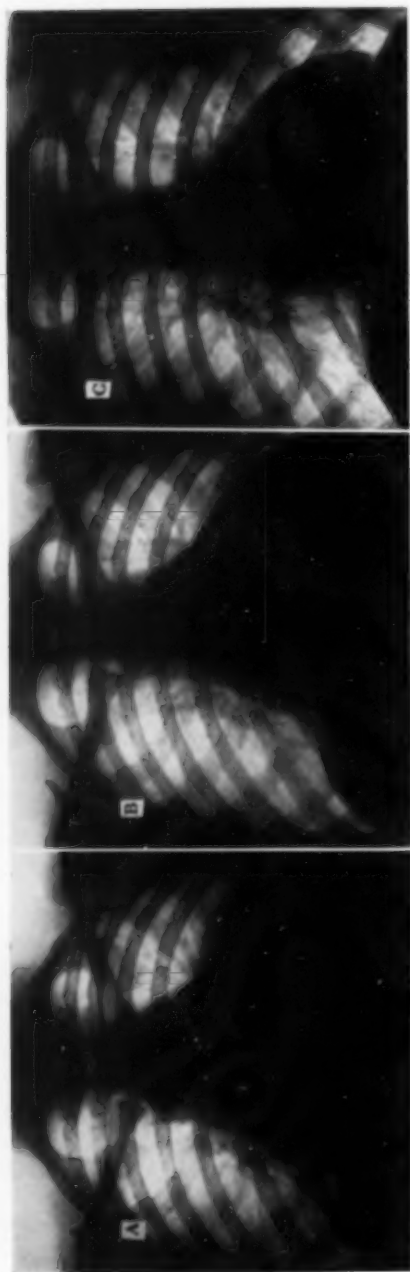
(Case No. 3) Effect of local hydrocortisone acetate on pleural and pericardial effusion: (A) Roentgenogram showing pleural and pericardial effusion before treatment; (B) 8 days after the introduction of 100 mg of hydrocortisone into the left pleural cavity; (C) 9 days after a second introduction of 75 mg. of hydrocortisone; complete recovery.
